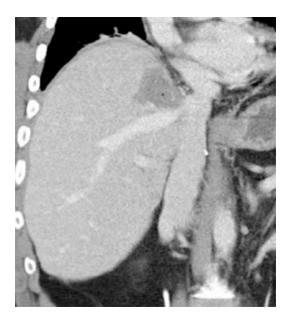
CT image of post-IRE treatment (*dark area*) of a colorectal carcinoma near right atrium, diaphragm, and hepatic vein IVC confluence. Successful procedure without damage to these structures and no post-procedure pain (From Ref. [39] with permission)
